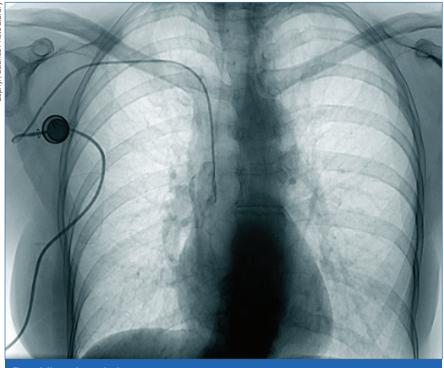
X-ray of a port in situ
